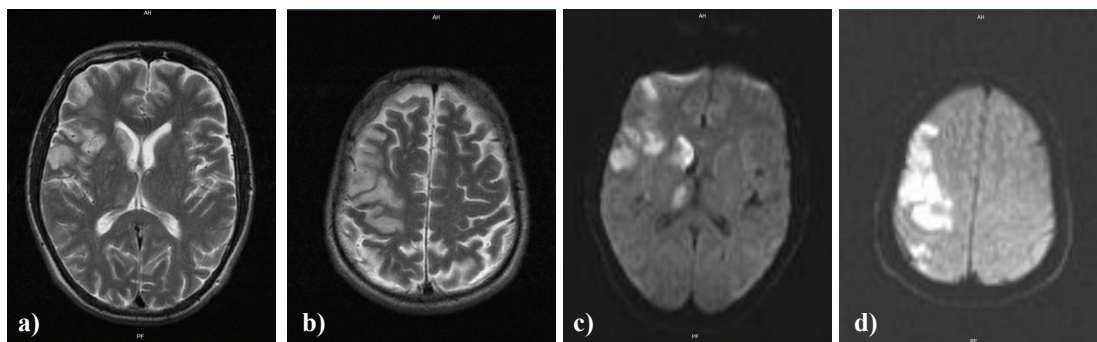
Axial images of brain magnetic resonance imaging showing multiple embolic strokes in the right middle cerebral artery territory; a) and b) T2-weighted sequence, c) and d) diffusion-weighted sequence.
